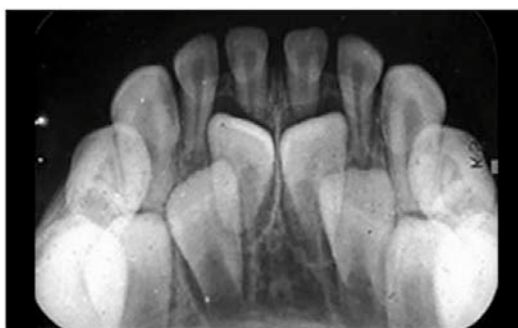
Periapical radiograph of primary mandibular anterior teeth.
